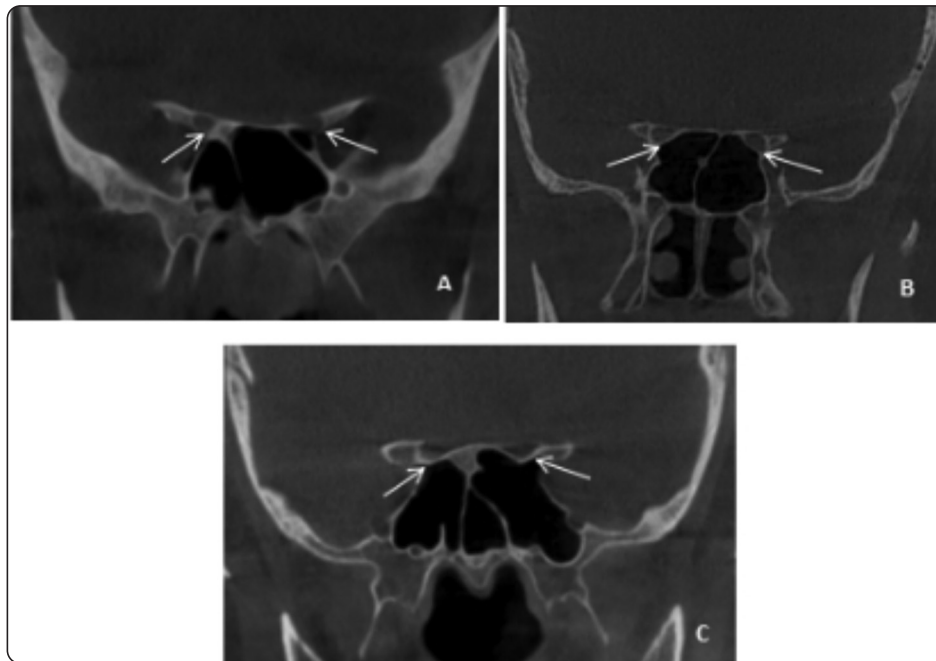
Coronal cuts of CBCT showing relation of sphenoid sinus to the optic nerve (ON): A: smooth (irrelevant), B: smooth (touching) and C: prolonged type (protrusion less than 50%).
